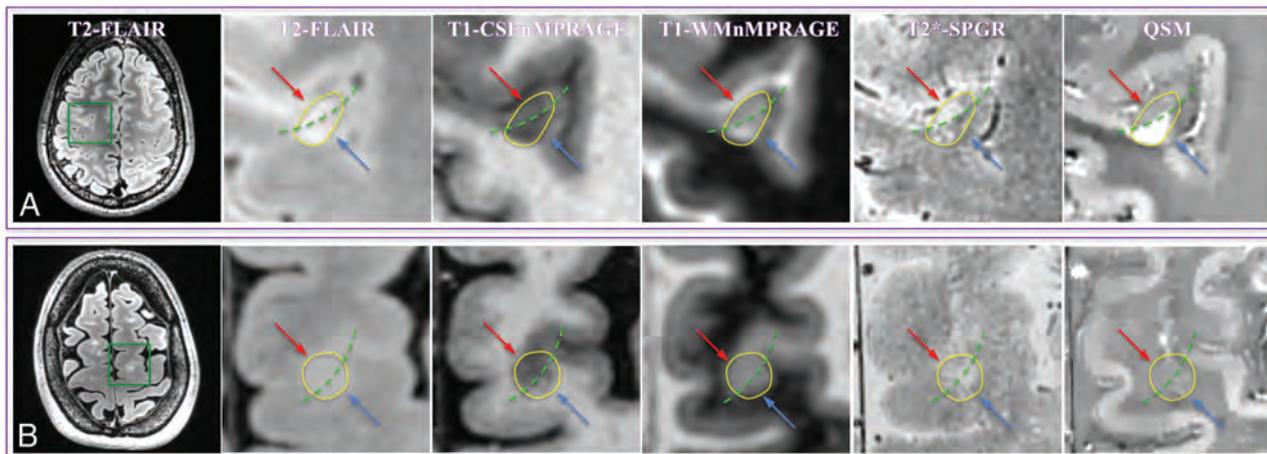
MR images of representative mixed lesions (yellow circles) from patients 1 (A) and 6 (B). The green dashed line divides a mixed lesion into its cortical (red arrow) and WM (blue arrow) components. A, The lesion has a QSM hypointense cortical portion and a hyperintense WM portion relative to adjacent normal-appearing GM and normal-appearing WM, respectively. B, The cortical component is hypointense compared with normal-appearing GM, while the white matter component is centrally isointense but peripherally slightly hyperintense compared with normal-appearing WM. Please see the Fig 3 legend for image descriptions.
